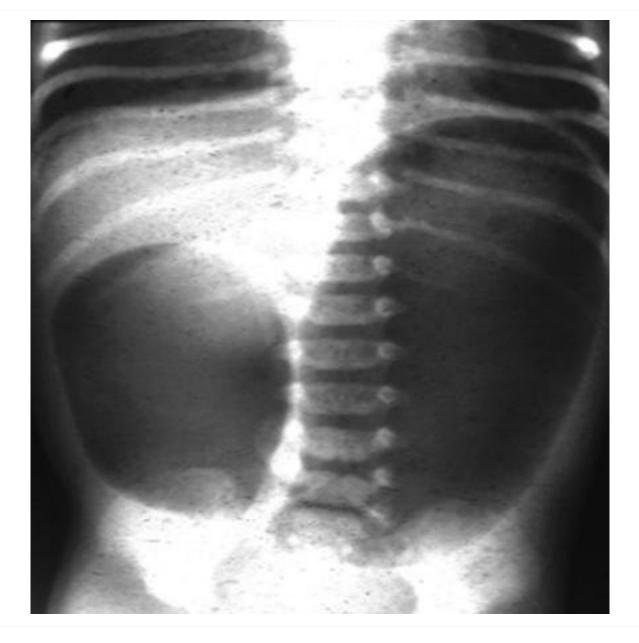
Abdominal x-ray demonstrating double bubble gas pattern consistent with duodenal atresia From the collection of Dr KuoJen Tsao; used with permission
